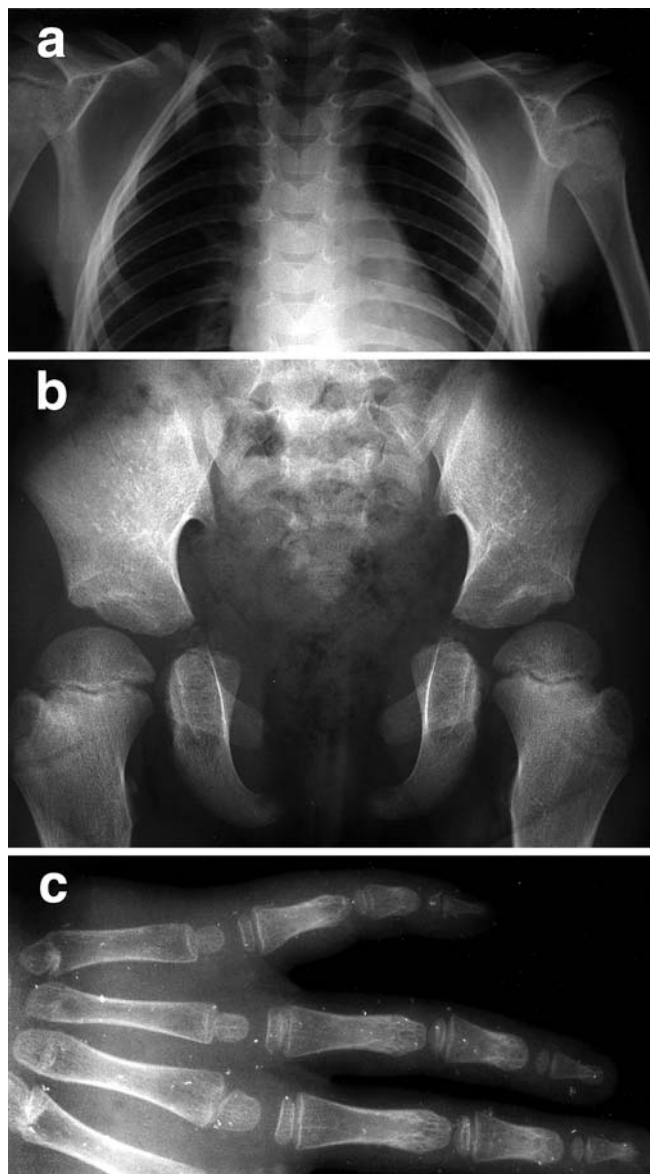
Radiological features of Case 2. a Chest film at 8 years of age: the posterior arches of the thoracic vertebrae are not completely fused, the right clavicle consists of two dysplastic parts. b Pelvic X-ray film at 8 years of age: narrow pelvis, dysplastic superior part and aplastic inferior part with open symphysis. c Plain film of the hand at 4 years of age: pseudo-epiphyses at metacarpals, clinodactyly of the fifth finger, cone-shaped distal phalanges
